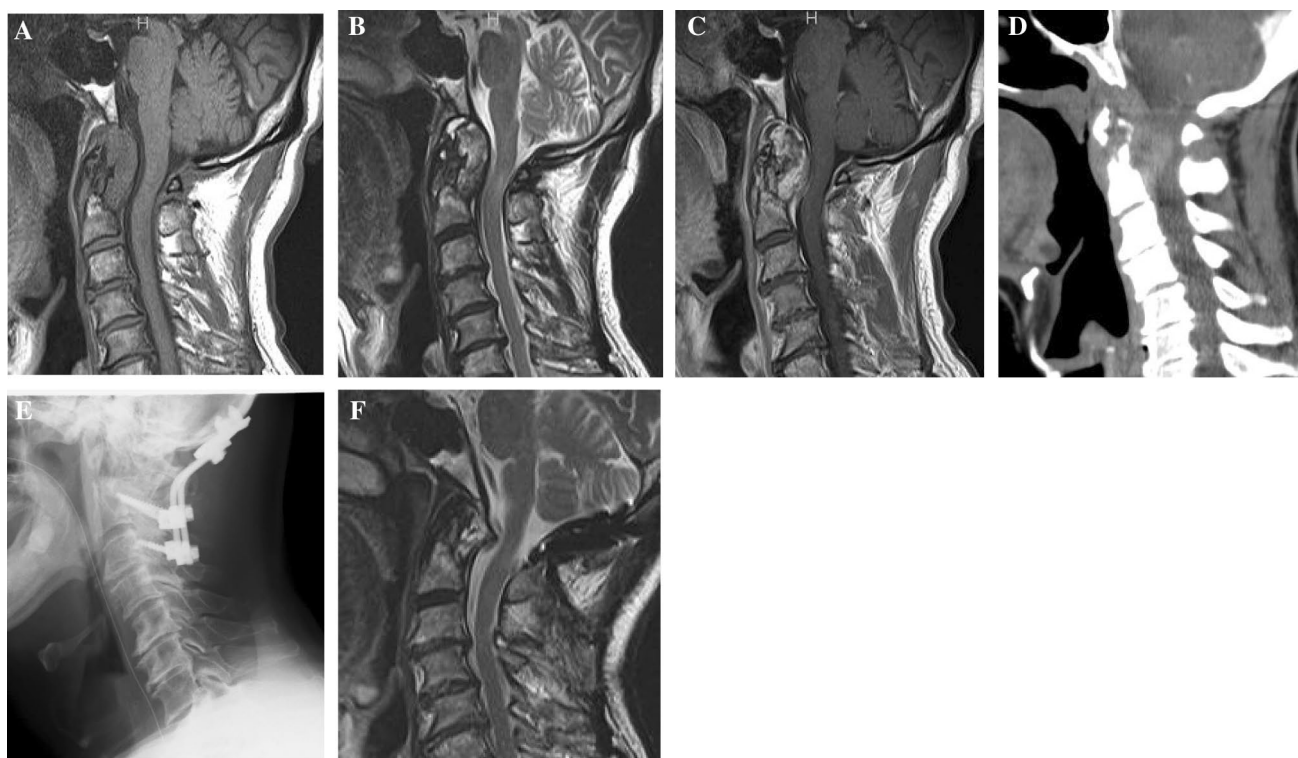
Case 1: a, b retro-odontoid pseudotumor detected on sagittal T1- (a) and T2-weighted MRI (b). c, d Capsular enhancement shown by Gd-enhanced MRI (c). d Sagittal CT showing a retro-odontoid
